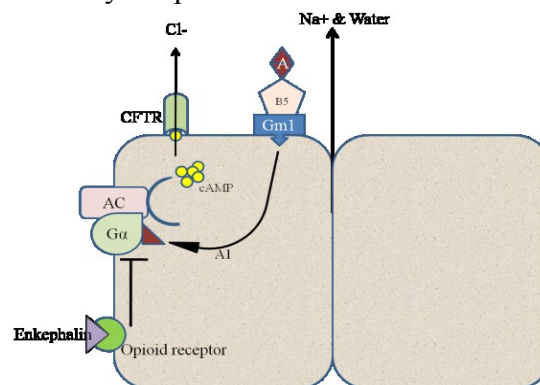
Mechanism of action of Cholera Toxin (CT).
